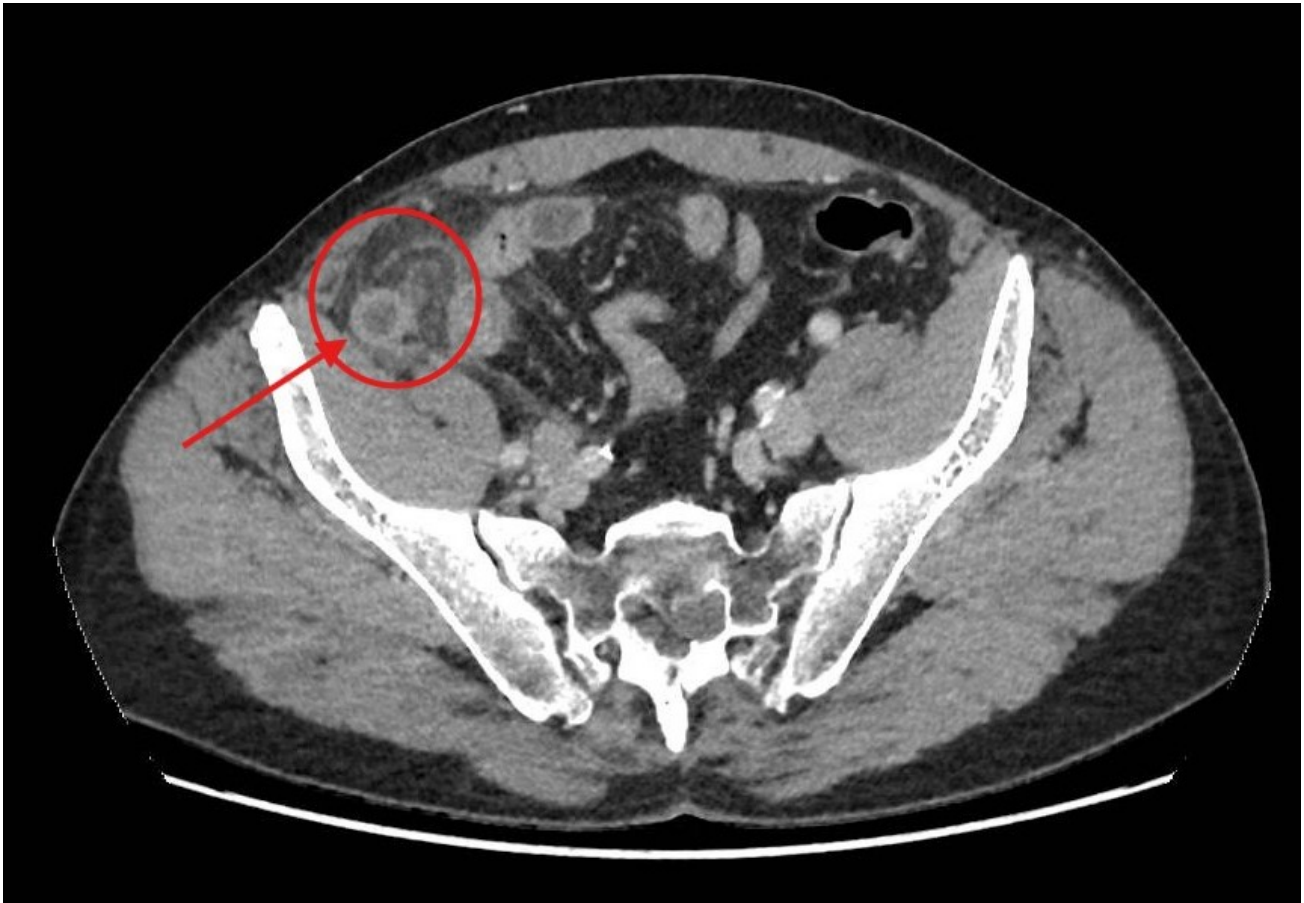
Contrast-enhanced CT scan. The red arrow indicates appendiceal enlargement with wall thickening, while the red circle highlights periappendiceal inflammatory changes. CT, computed tomography.
